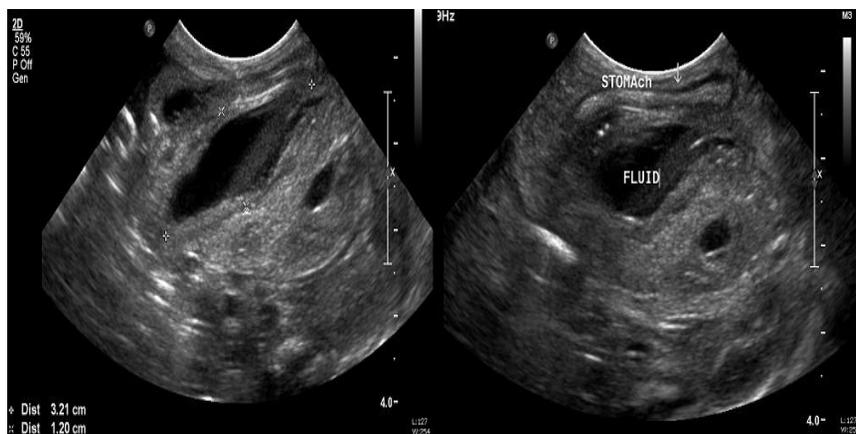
Hemo- and pneumoperitoneum at the posterior aspect of the stomach lower body and antrum were identified by abdominal sonography.
